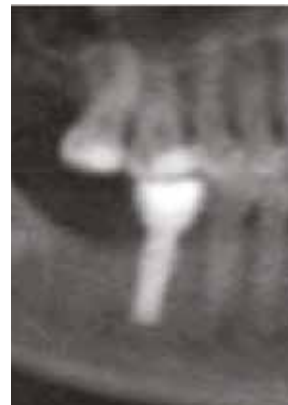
Following 4 months of daily use of the LMHFV, the radiolucency has resolved and increased osseous density is noted on the CBCT PAN view.
